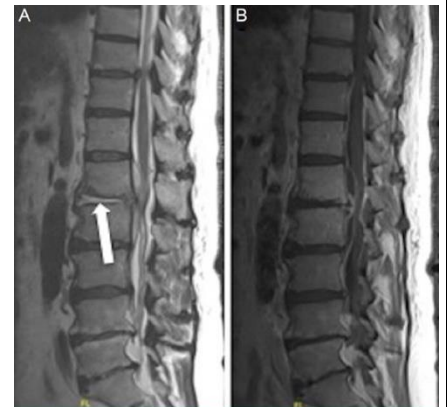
Discitis with associated ventral epidural abscess. Lumbar magnetic resonance image of a patient with diabetes mellitus who presented with acute on chronic low back pain, fevers, and weight loss. Sagittal T2 fluid-attenuated inversion recovery (FLAIR) imaging (A) and T1 postcontrast imaging (B) show high T2 signal within the L1-L2 intervertebral disc (arrow) and an associated ventral epidural fluid collection with peripheral enhancement. Blood cultures grew methicillin-sensitive *Staphylococcus aureus*.
